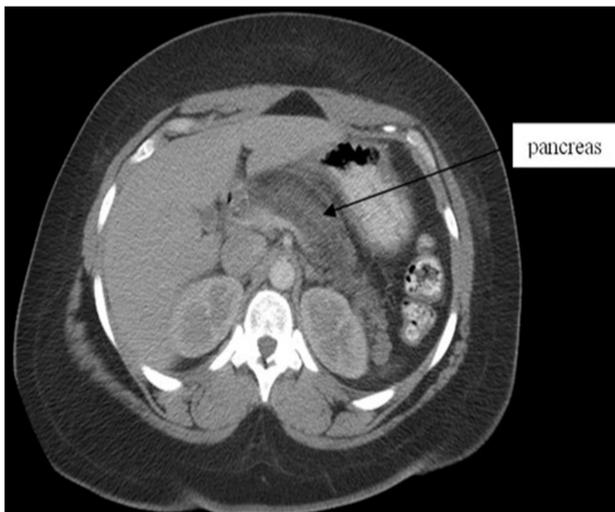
CT scan of abdomen with contrast
